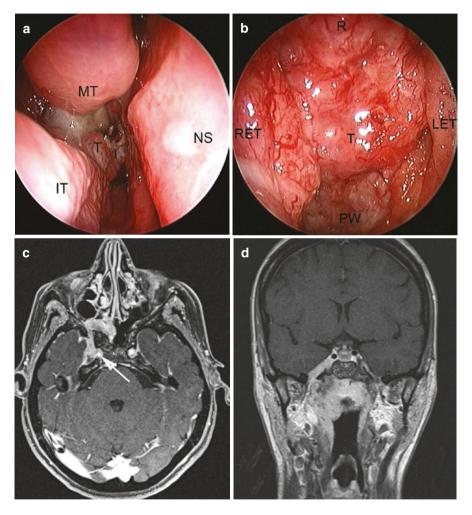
Nasal endoscopy shows an AdCC reaching the right choanal region (a) and involving the entire nasopharyngeal surface with mucosal spreading over the right eustachian tube (b). At MRI (c, d), the lesion is found to have macroscopic intracranial extension along trigeminal branches with right ICA encasement (arrow in c) and cavernous sinus involvement. The lesion was deemed not suitable for surgical treatment, and the patient underwent exclusive radiotherapy (*IT* inferior turbinate, *LET* left eustachian tube, *MT* middle turbinate, *NS* nasal septum, *PW* posterior nasopharyngeal wall, *RET* right eustachian tube, *T* tumor)
